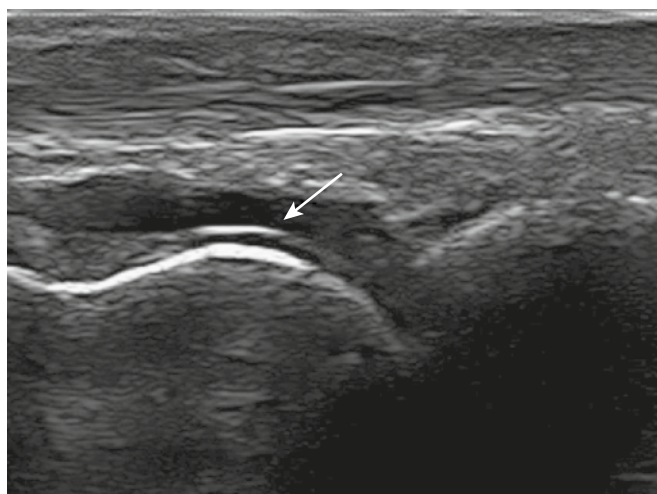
Ultrasound shows a cartilage interface artifact (arrow) at the superficial hyaline cartilage-fluid interface.
